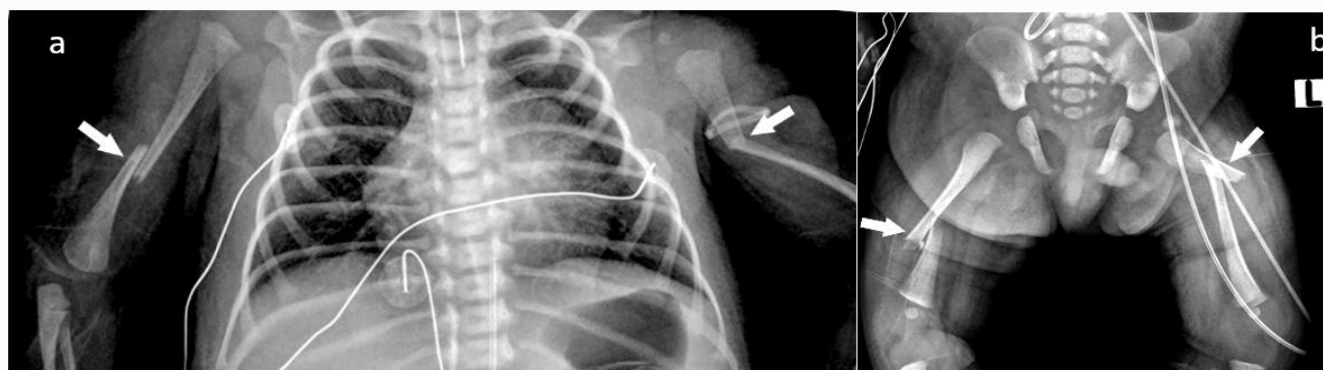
Radiographs of the chest (a) and the pelvis (b), showing bilateral fractures of the humeral and femoral bones (arrowheads). Note the gracile appearance of the ribs and the underdeveloped scapulae and pelvic bones, possibly related to intrauterine fetal hypokinesia.
